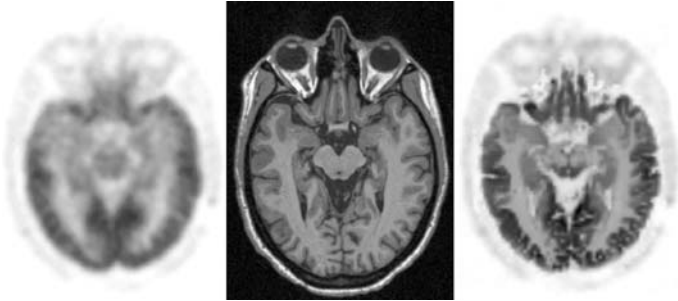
PET image obtained with MAP-reconstruction without (left) and with (right) the use of anatomical information from a registered MRI image (center), using a tissue composition model.<sup>43</sup> The 3D sinogram was first rebinned with FORE,<sup>44</sup> then the MAP-reconstructions were computed.<sup>12</sup>
